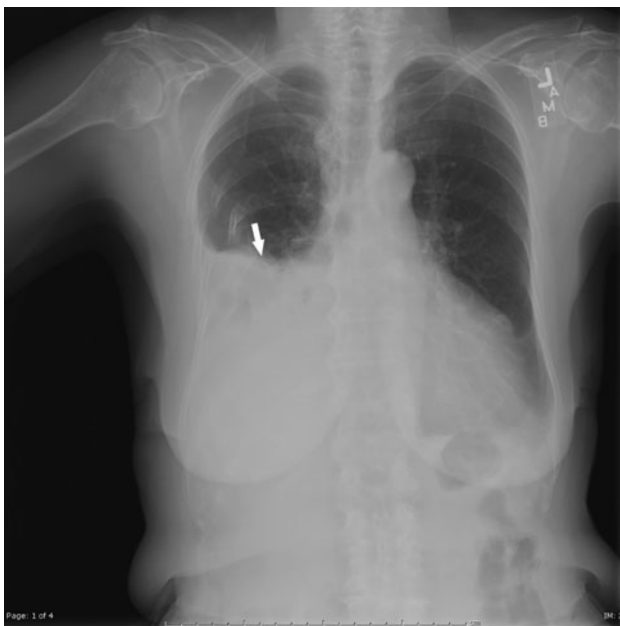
Repeat chest radiograph revealing a new, large right-sided pleural effusion and the posterolateral rib fractures. The arrow points to the new pleural effusion
